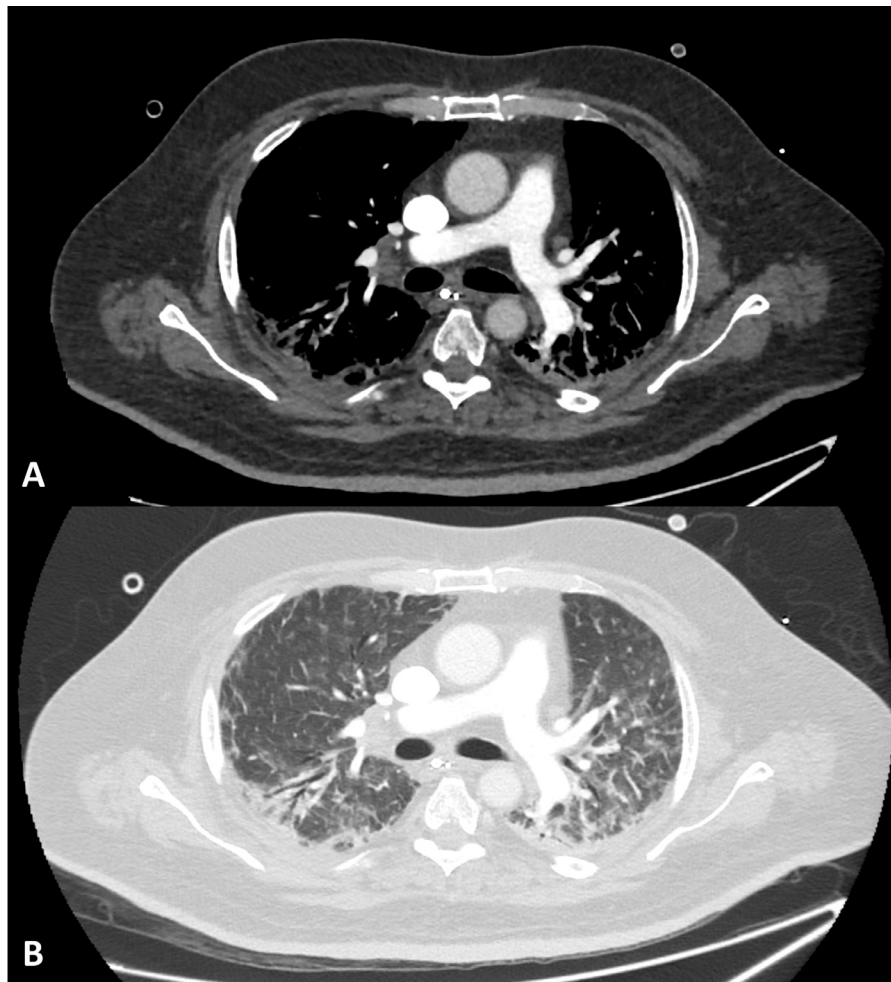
CT pulmonary angiogram after 3 weeks. (A) Complete resolution of the saddle pulmonary embolus. (B) Lung parenchymal appearances have markedly improved with mild residual bilateral patchy ground glass attenuation and peripheral consolidation.
